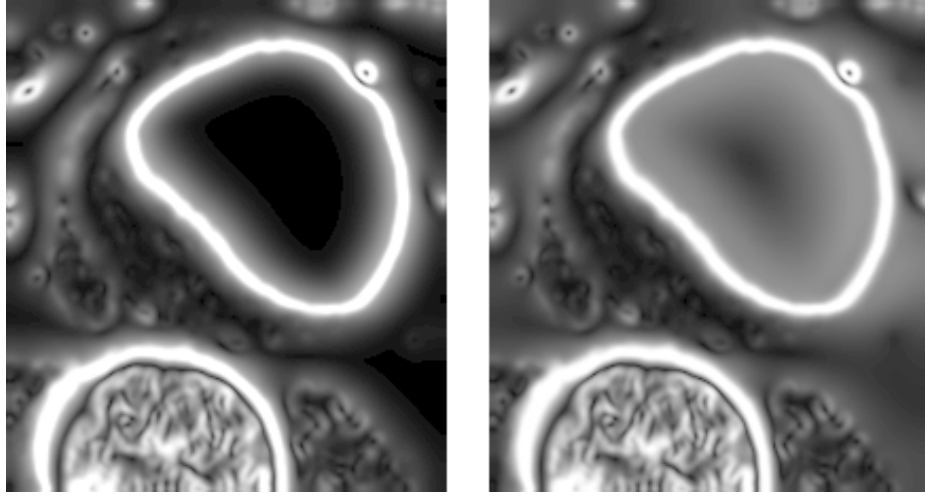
Magnitude of the vector field after running gradient vector flow (GVF) on a AAA CT dataset. Left: Euler's method with 1000 iterations. Right: Multigrid method with 6 iterations. The image to the left shows that GVF with Euler's method has problems with diffusing the gradients on the edge of the aneurysm to the center which is necessary for the TDFs.
